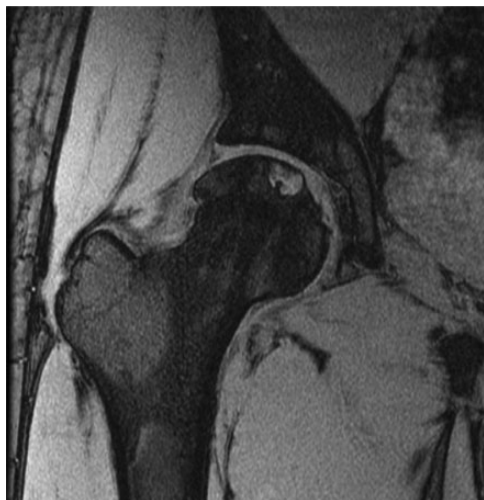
Magnetic resonance imaging 19 months after injury demonstrates no intra-articular pathology, successfully ruling out pigmented villonodular synovitis. Redemonstration of an enlarging subchondral cyst without collapse of the subchondral plate.
